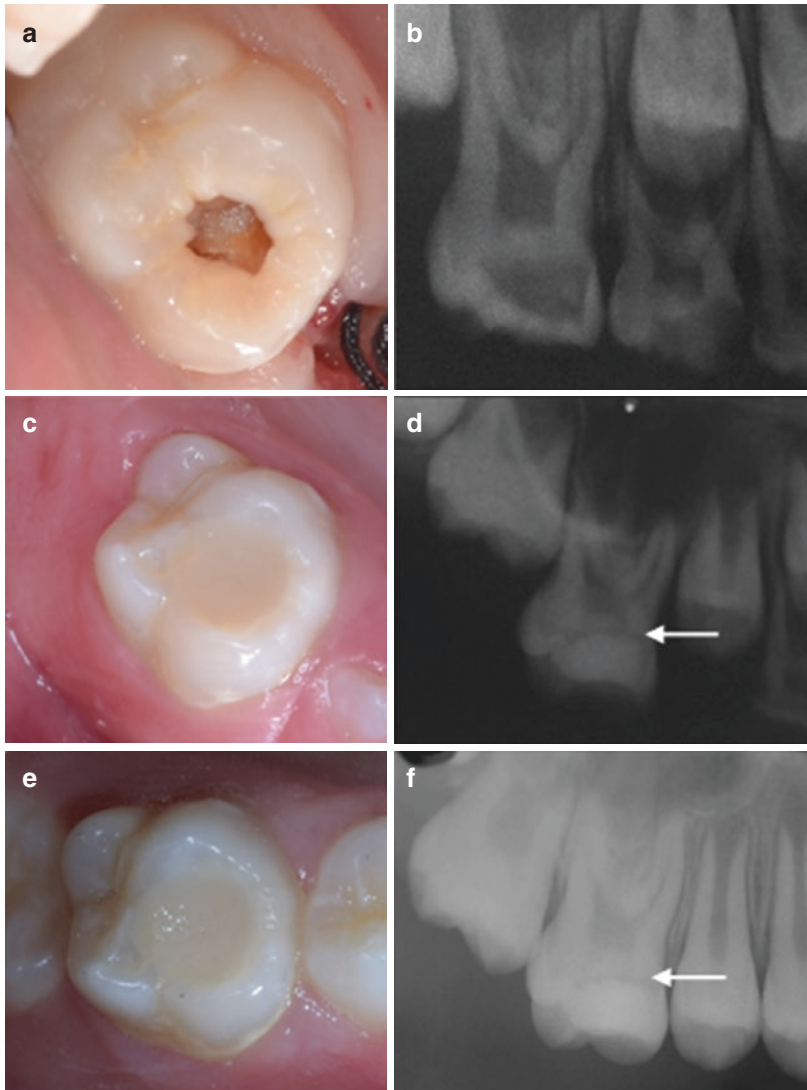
(a) Clinical aspect of a cavitated dentin carious lesion on the occlusal surface of a first permanent molar; (b) the radiography in which a deep carious lesion is observed; (c) the same tooth after 8 months of receiving a restoration; (d) the arrow indicates a dark zone underneath the restoration, indicating that selective carious removal was used to clean the cavity to avoid pulp exposure; (e) the clinical aspect of the restoration after 24 months; (f) the procedure is radiographically successful, although a demineralized zone under the restoration is still observed (arrow)
